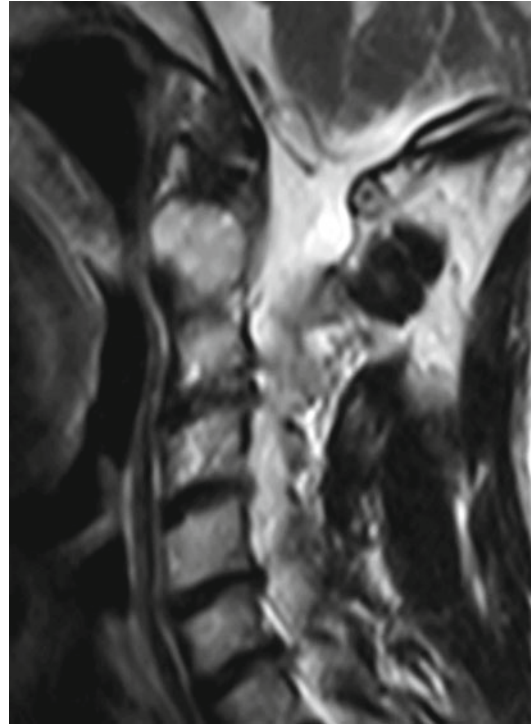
56 year old male with history of metastatic renal cell carcinoma. Sagittal T2 MRI demonstrating a large mass within the C2 vertebral body without significant extension into the spinal canal or cord compression
